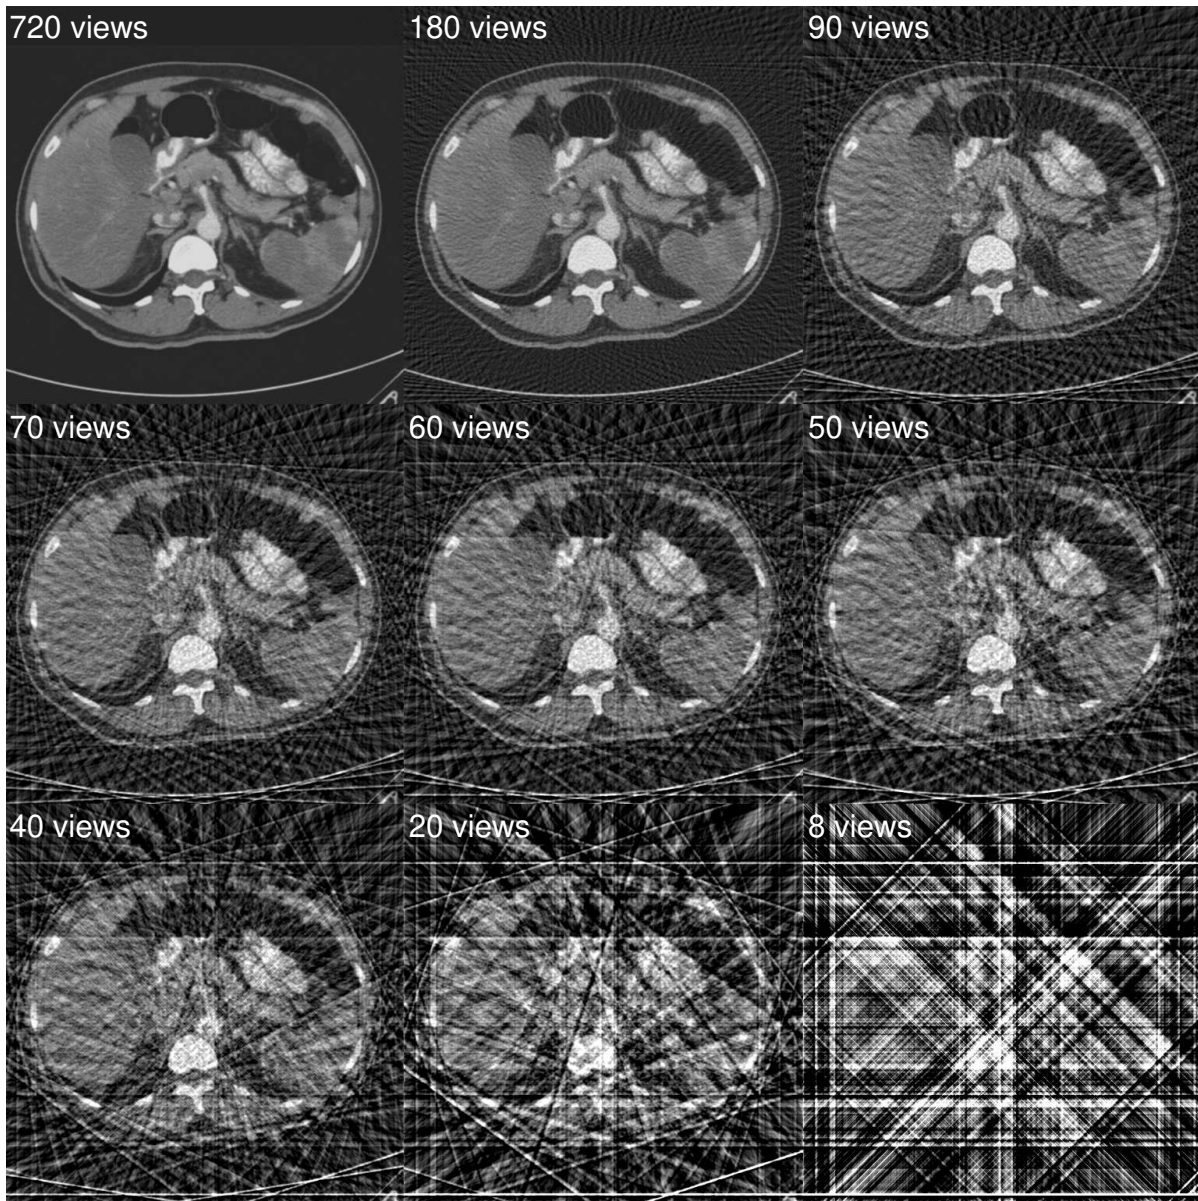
Undersampling in the number of views can cause significant aliasing in CT reconstruction. When 720 views per rotation is sampled, the reconstruction shows superior image quality with an FBP algorithm. As the sampling rate decreases to 8 views per rotation, strong aliasing artifacts completely diminish the image quality.
